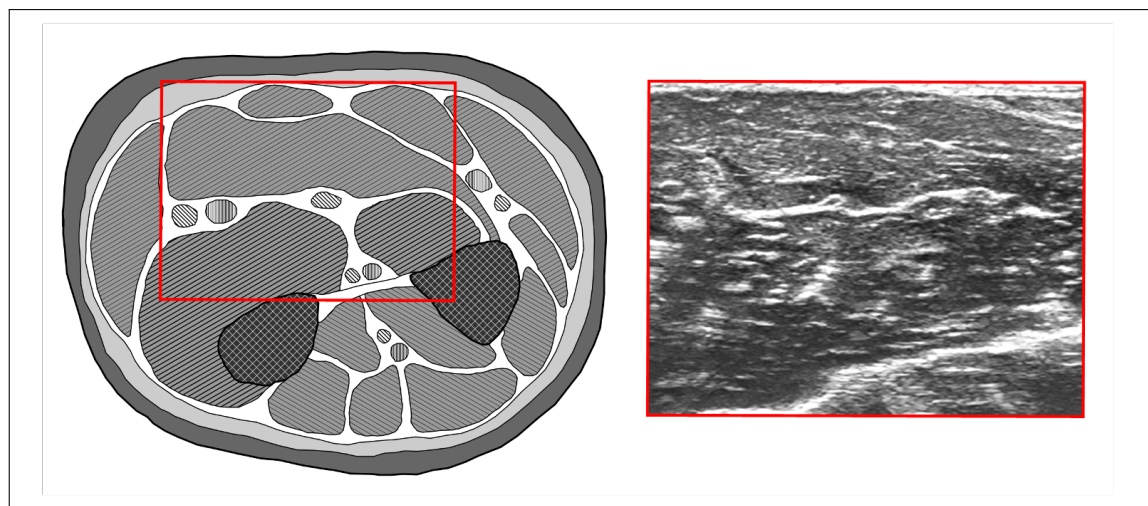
Anatomical image compared to ultrasound image (cross section B)
